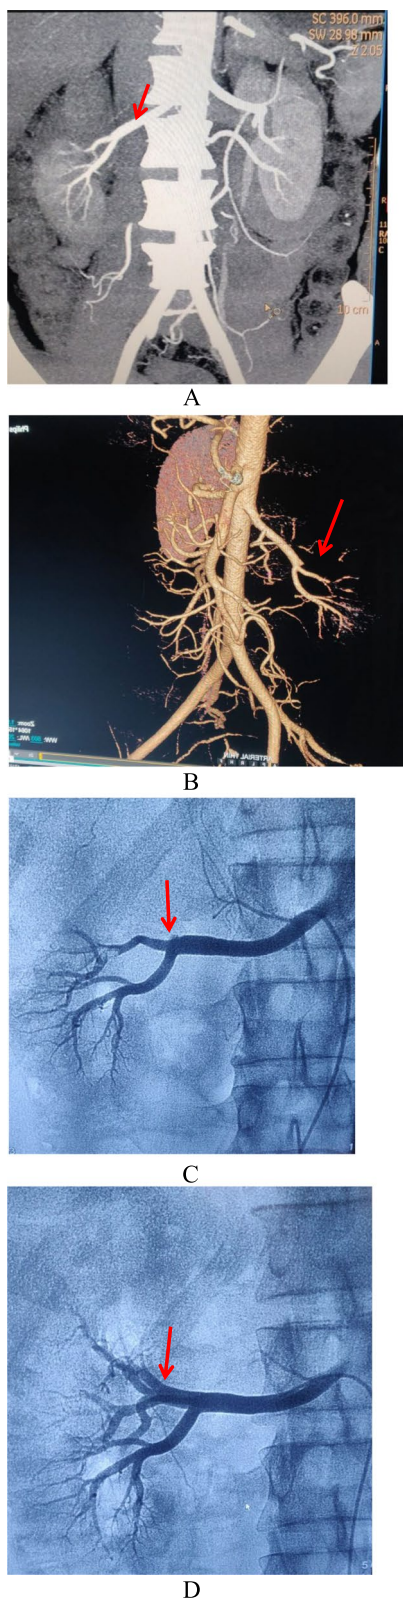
A Nonenhancing right renal infarct in upper and interpole renal parenchyma and right upper pole segmental renal artery thrombosis. B CT angiogram-3D image — showing right segmental renal artery thrombosis. C Renal angiogram showing right upper pole segmental artery thrombosis and catheter-directed thrombolysis. D Post thrombolysis resolution of clot
